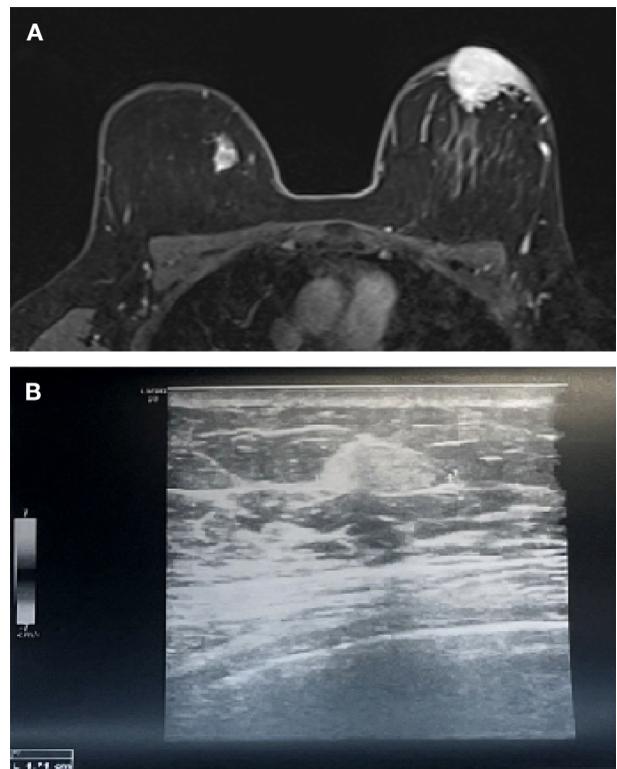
3T MRI. The image on the axial plane of a T1-weighted 3D acquisition of the first post-contrast dynamic frame: poly-lobed, irregular lesion with alternating heterogeneous enhancement and relatively hypovascularized central areas in the left retro-areolar region.
